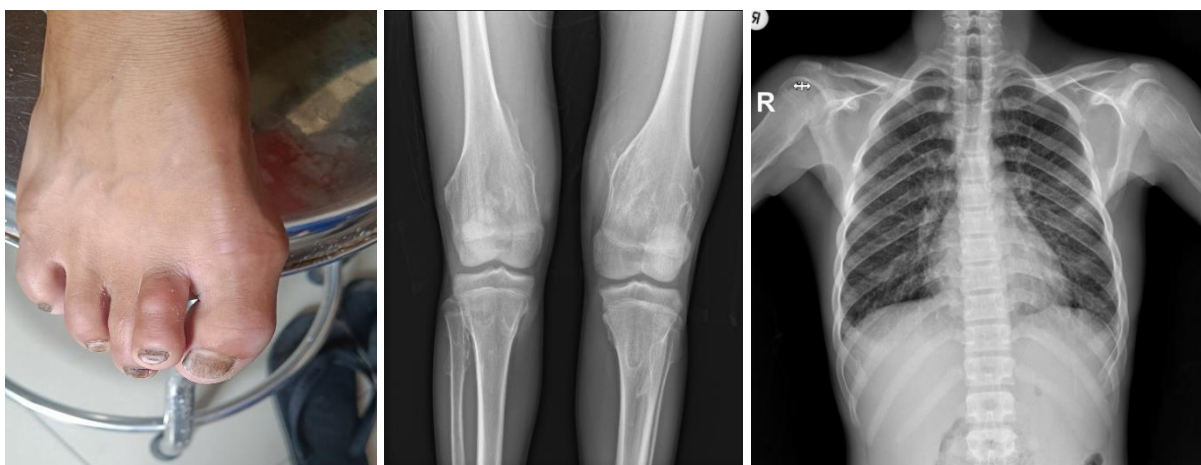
Clinical photograph of right foot showing swelling in first and 2nd toe; Figure 2. Radiograph of bilateral knee showing bony outgrowth from femur, tibia and fibula. Similar radiological changes were seen in other x-rays; Figure 3. Radiograph of chest showing bony outgrowth in left humerus
